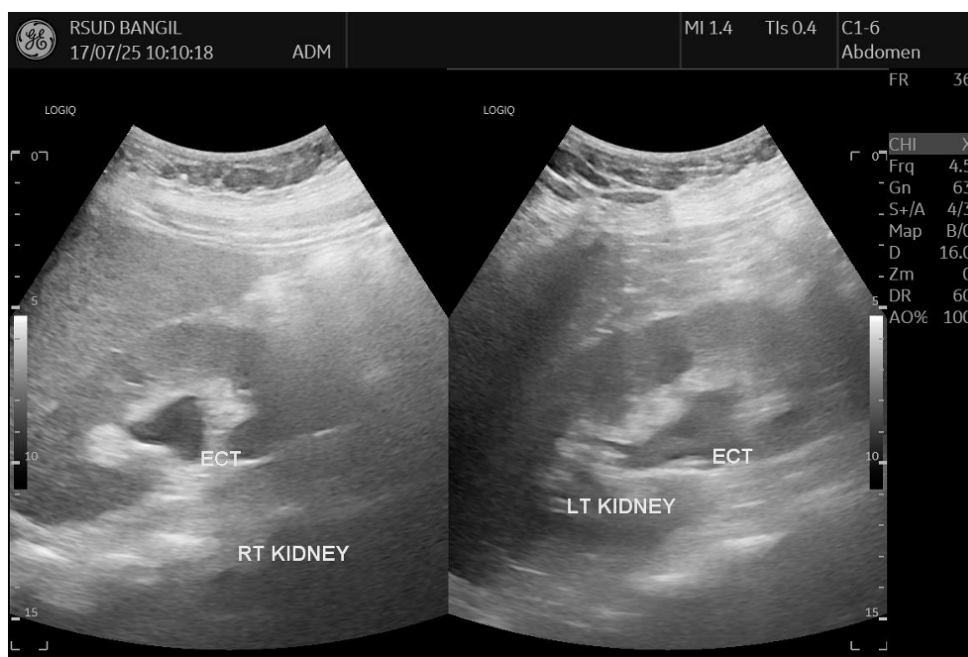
First-admission abdominal ultrasonography showing bilateral pelvicalyceal ectasia suggestive of hydronephrosis.
